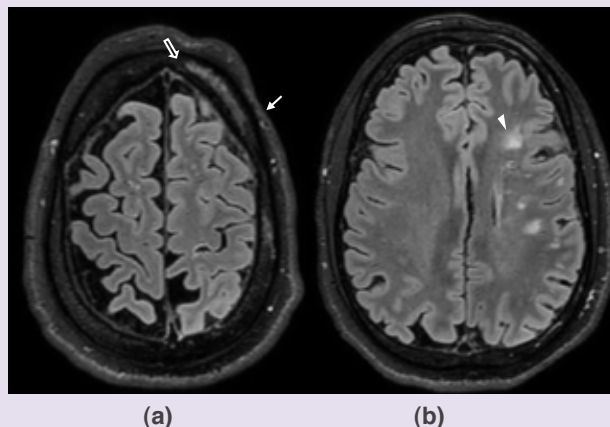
3D FLAIR images show soft-tissue volume loss involving the left half of the frontal scalp (↓) with thinning of the underlying left frontal bone, which also shows marrow hyperintensities (⇓). The adjacent brain parenchyma shows no atrophy; however, multiple punctate FLAIR hyperintensities are seen in the left frontal white matter.
